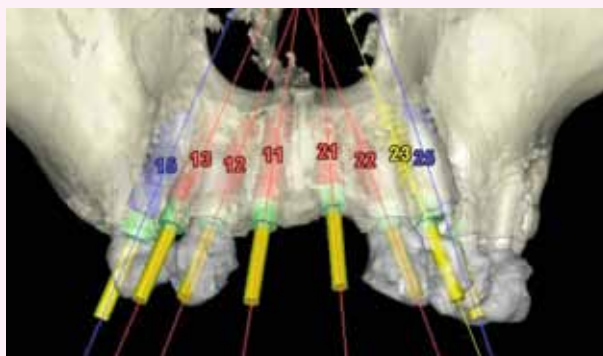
Interactive planning on the 3-dimensional image using the Siplant software. Each implant position can now be transferred to a stereolithographic model constructed from CT scan data. In addition a drill guide can be created from the same data, which will transfer the implant position from the planning directly to the mouth. The Expertease system permits precise positioning in terms of angulation as well as depth.
